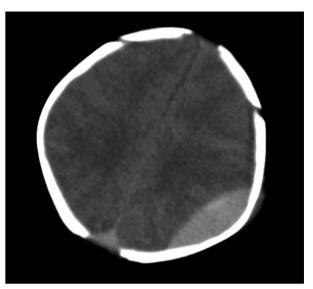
Pre-operative axial non-contrast brain CT that shows a lenticularly-shaped hyperdensity, consistent with an epidural hematoma, exerting a mass effect on the adjacent left parietal lobe.
